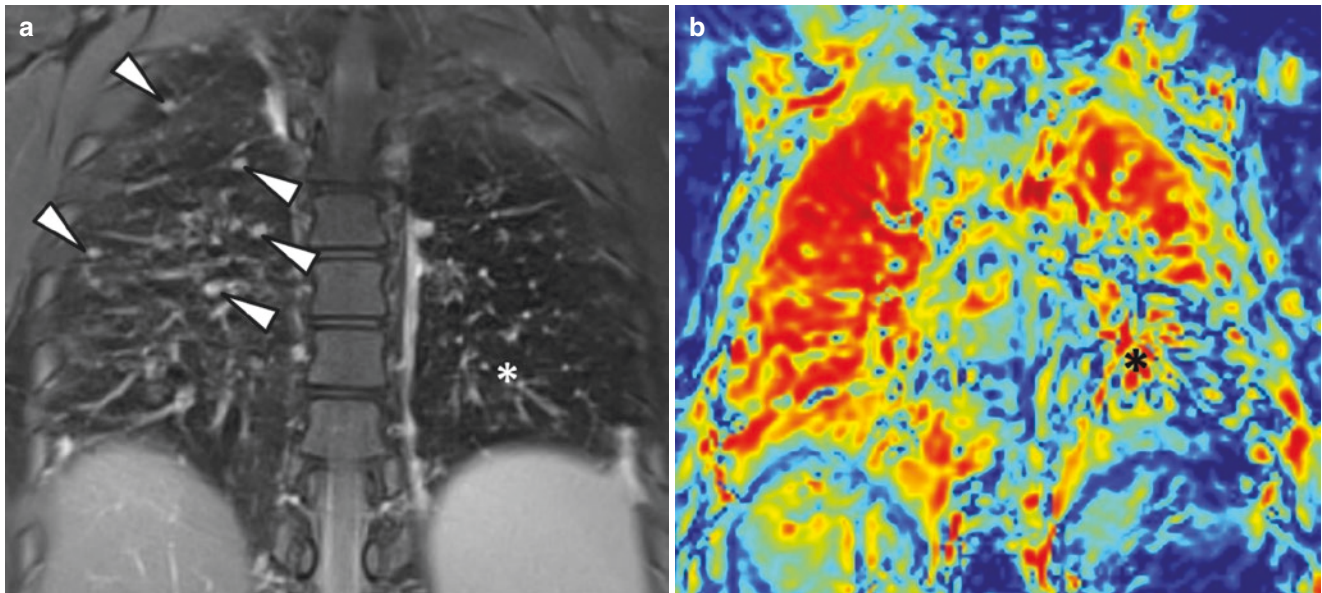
A 19-year-old-girl with common variable immunodeficiency. (a) Coronal T2-weighted MR image with fat suppression shows multiple nodules in the right lung (arrowheads) representing lung granulomas and a large area of low signal intensity in the left lower lobe
